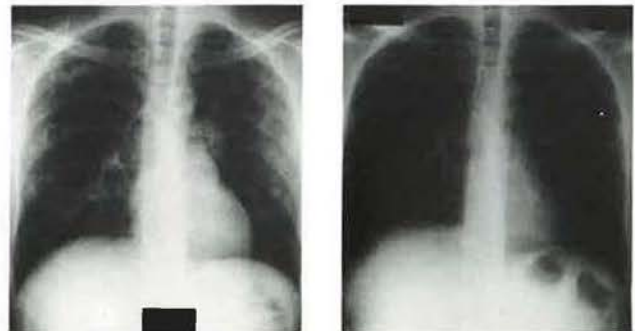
Chest roentgenogram (a) on admission. Multiple nodular infiltrates were noted in bilateral upper and middle lung fields without pleural effusion. (b) Gradual clearing was noted after treatments.
